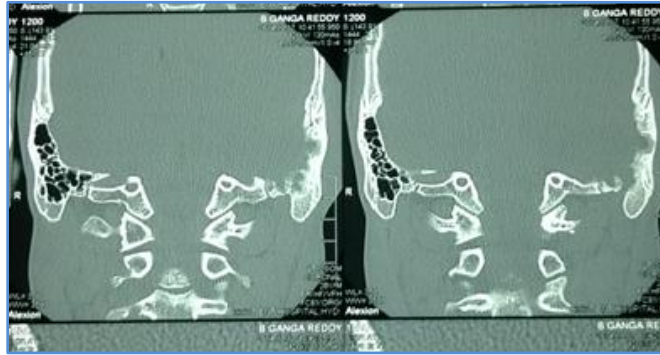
CT scan Temporal bone
